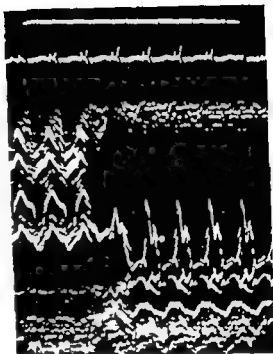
Echocardiogram of a 13 month old girl with severe congestive cardiomyopathy. The transducer was tilted from the aorta (left side of the picture) to the mitral valve and the left ventricle while the picture was taken. The left ventricle is very dilated, the mitral valve apparatus is dislocated posteriorly, the septum is dislocated anteriorly. The baby died and the autopsy showed a very dilated left ventricle with endocardial fibroelastosis.
